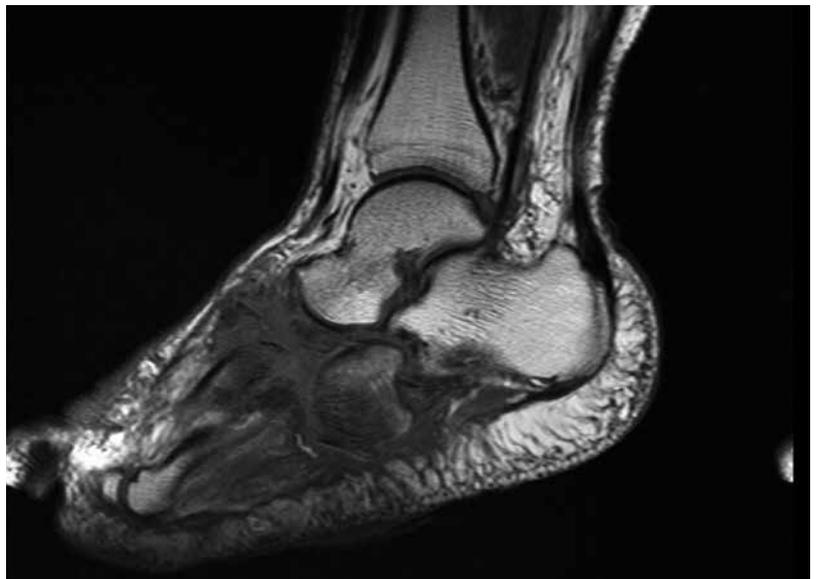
Charcot Foot MRI.
